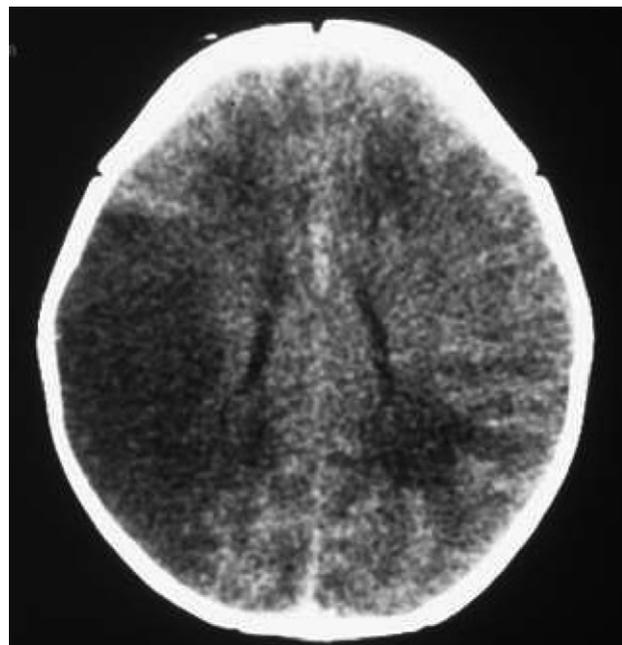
CT image of 1-day-old child diagnosed with right middle cerebral artery stroke.
